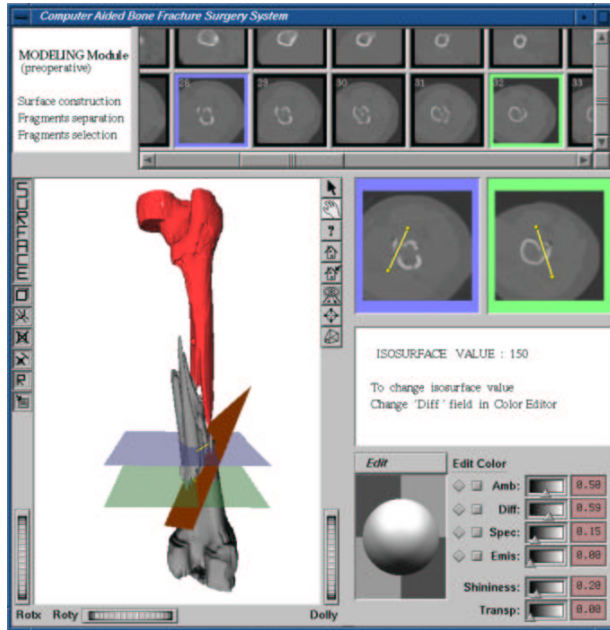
The modeling module, showing the CT slices (top window), the fractured bone surface model (left bottom window), and the detail of the selected CT slices (horizontal planes) used to define the cutting plane (slanted) separating the bone fragments.
